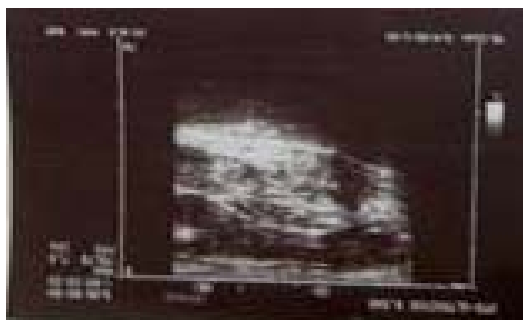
Preoperative ultrasound finding in the first patient.
